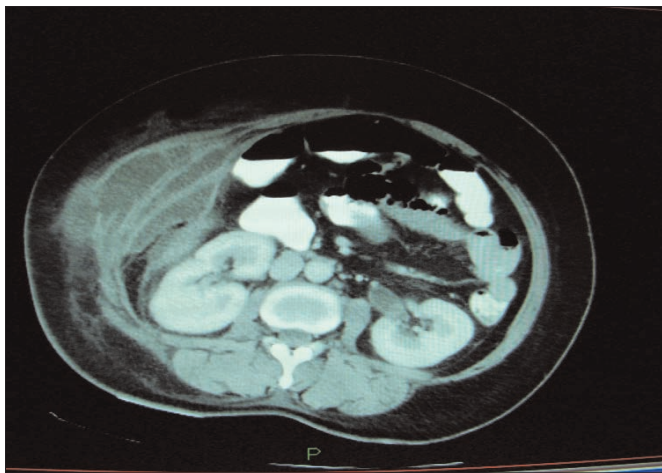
CT Scan abdomen showing multi-loculated abdominal wall abscess.
